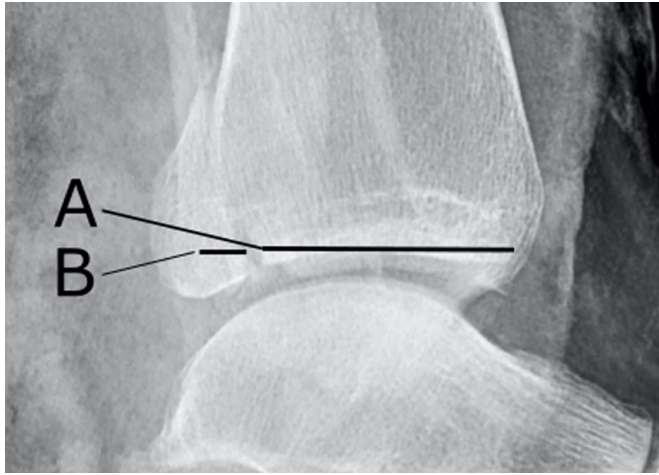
Measurement of PMF-size. The size of the posterior malleolus fracture was measured as percentage joint involvement (B) of the anteroposterior length of the distal tibial articular surface (A +B) on lateral radiographs of the ankle ( $(B/(A + B)) * 100 = \% \text{ size of the distal tibial articular surface}$ ).
